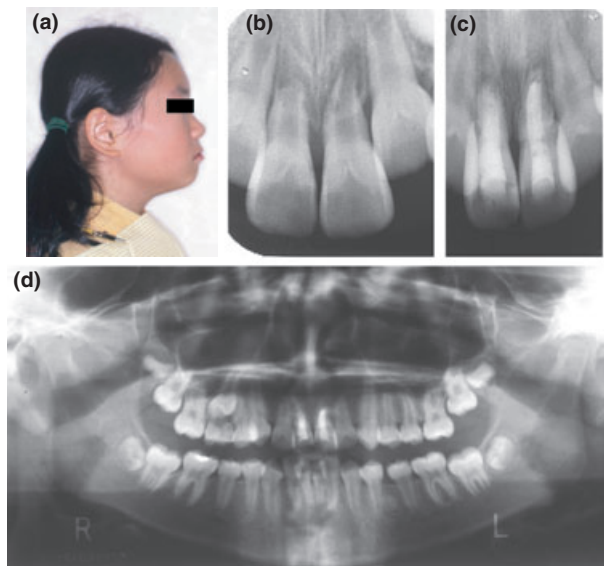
(a) Pretreatment facial photographs. (b) Dental radiograph obtained immediately after replacement of central incisors. (c) Dental radiograph obtained 4 years 6 months after replacement. (d) Panoramic radiograph obtained just prior to orthodontic treatment.
